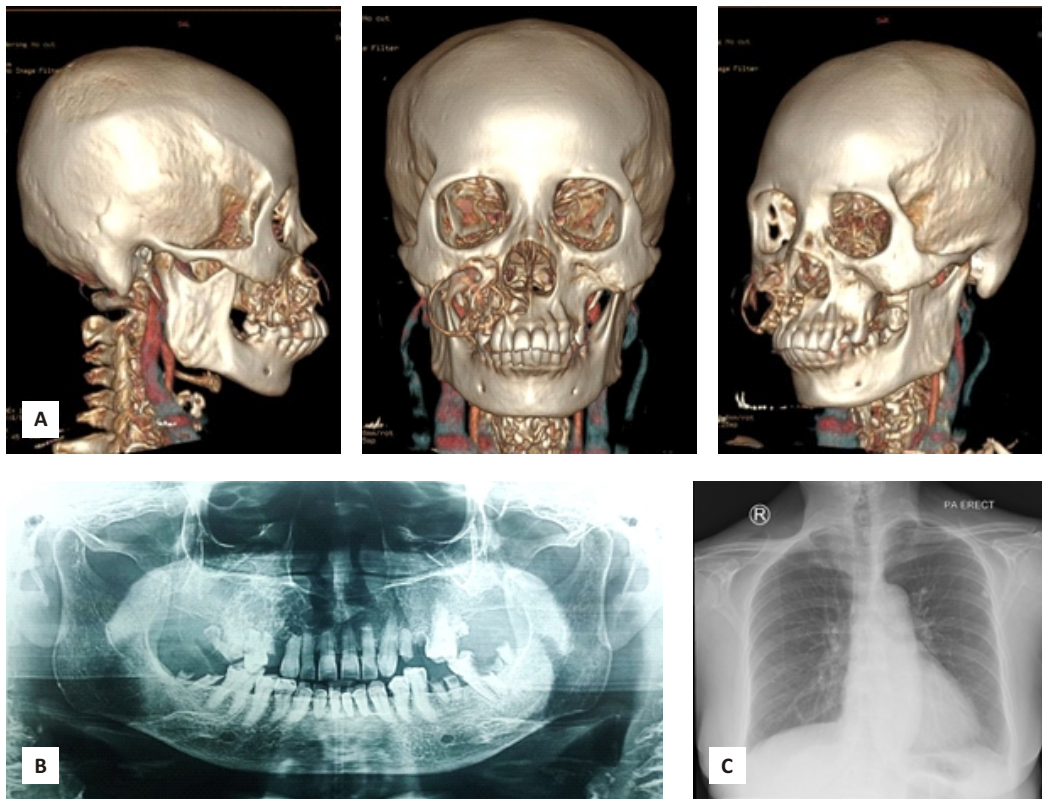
a. Radiographic CT scan of the head to assess the extent of the mass; b. Dental Panoramic Photo; c. Chest X-ray.
